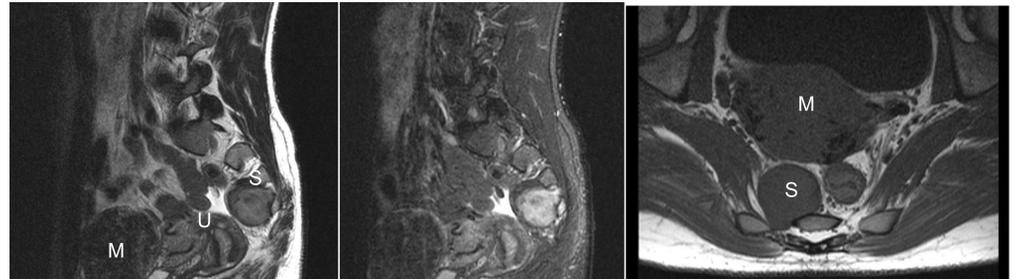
Sacral MRI. S: Schwannoma. U: uterus. M: mioma.
